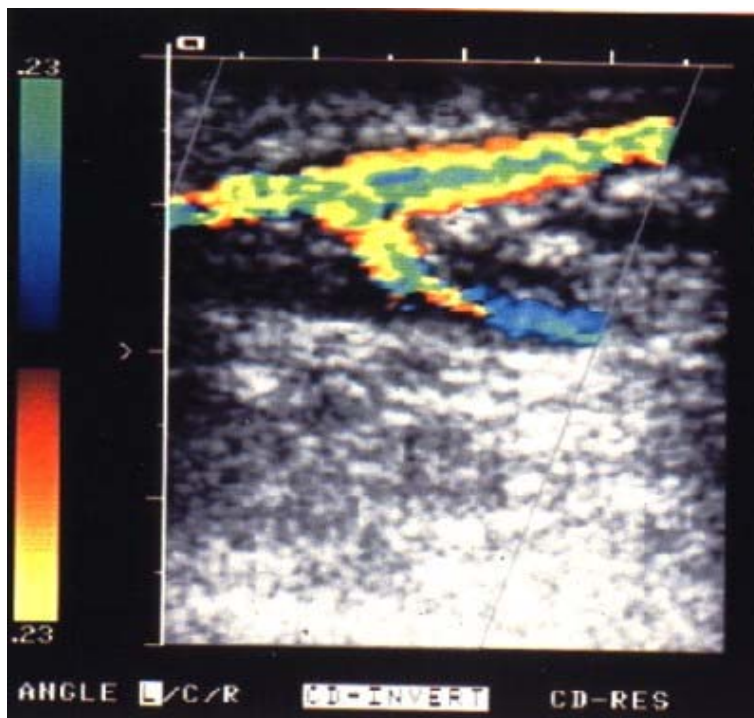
Colour flow doppler of carotid bifurcation
